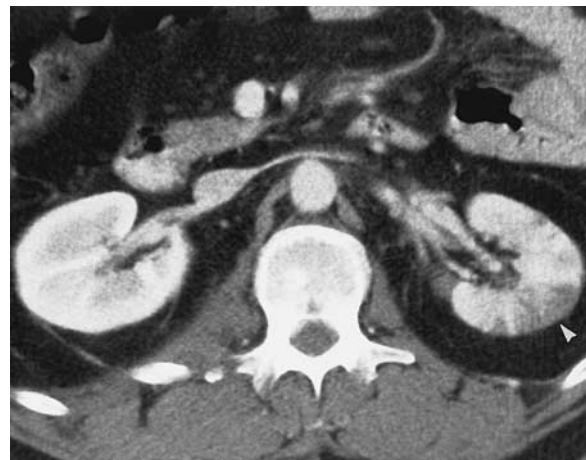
Renal contusion (category I) in a 46-year-old man who had sustained blunt abdominal trauma. Contrast-enhanced nephrographic-phase helical CT scan demonstrates a focal area of decreased contrast enhancement in the interpolar region of the left kidney (arrowhead).
